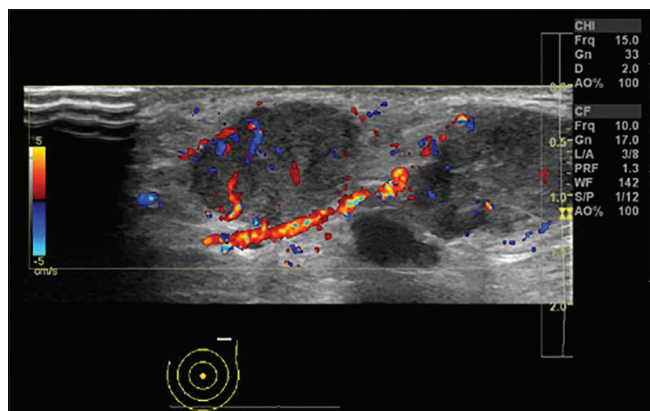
A 72-year-old female with known left breast cancer. Color Doppler image of metastatic LN with transcapsular feeding vessels unlike the normal appearance of hilar vessels.
